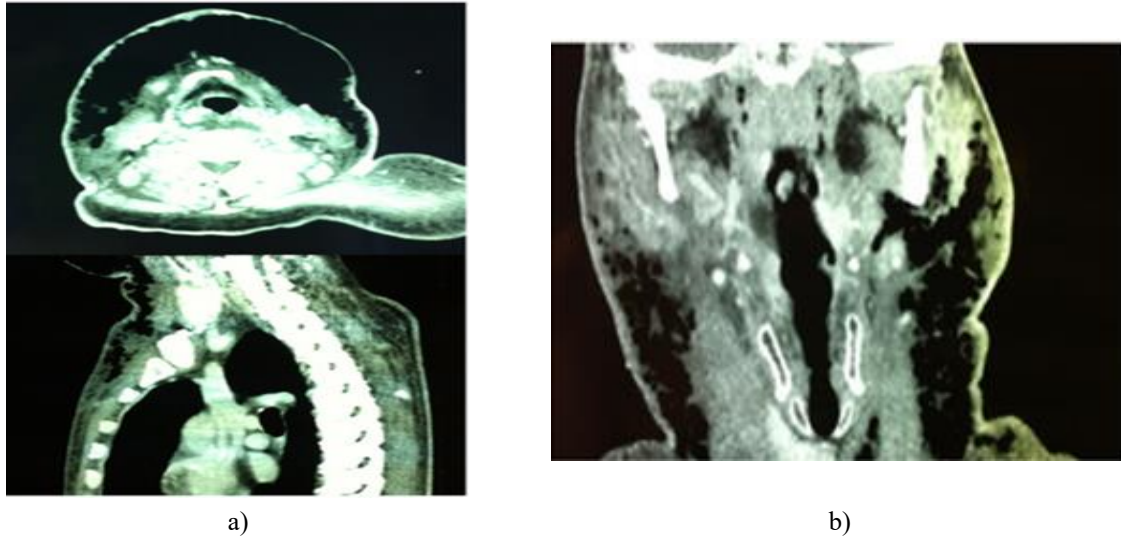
Patient A: Preoperative CT scan showing abundant gas extending subcutaneously from the upper anterior chest wall and the anterolateral neck bilaterally up to the paramandibular region.
